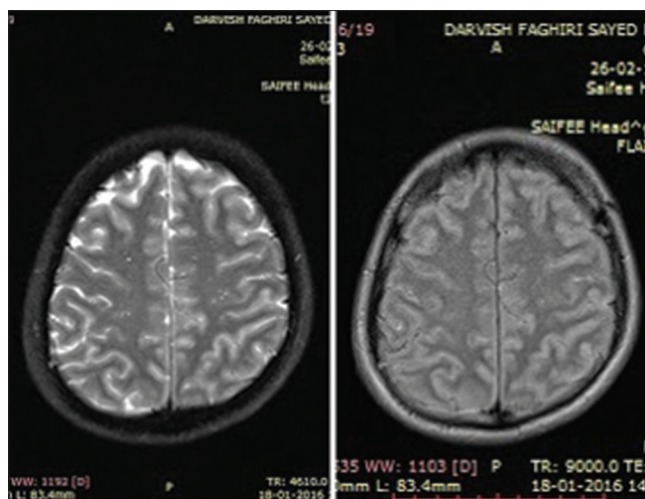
MRI study showing infarcts on FLAIR imaging and ADC maps
